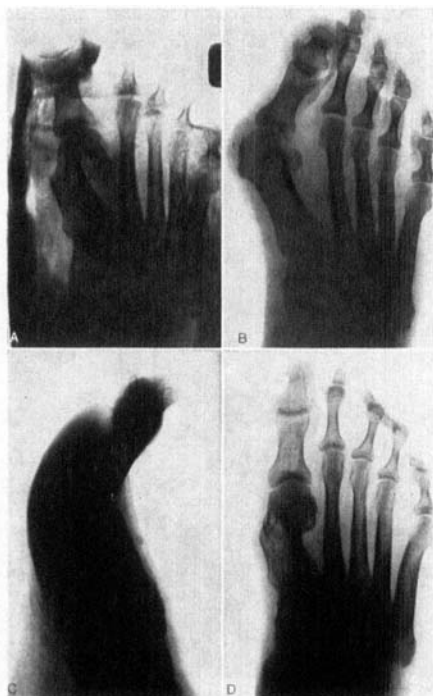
X-rays pre-operatively (top left), immediately post-operatively (top right), and the same foot 2 years later (bottom left and right).
